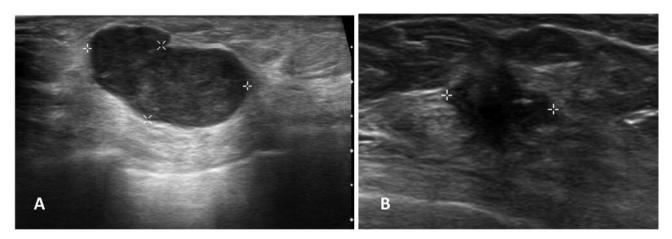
Ultrasound images of BL-TNBC with lobulated margins (A) and IM-TNBC with spiculated margins (B).
